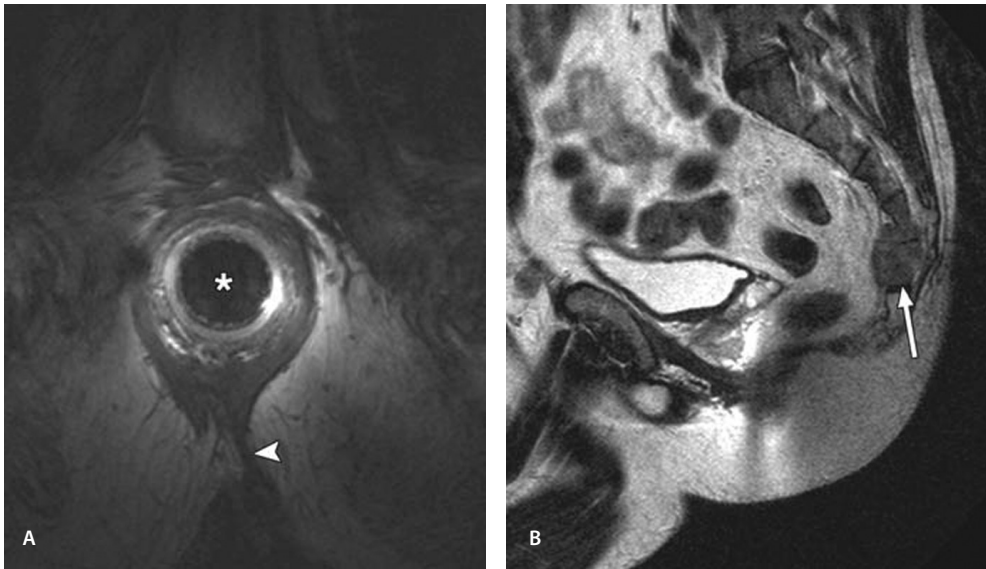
40-year-old man 17 years after surgical drainage of perianal abscess with persistent and increasing anal and perianal pain for almost 1 year with no abnormalities at proctoscopy or examination under general anesthesia. A, Endoanal MR image shows thickened anococcygeus ligament (arrowhead). Asterisk indicates endoluminal coil in anal canal.
